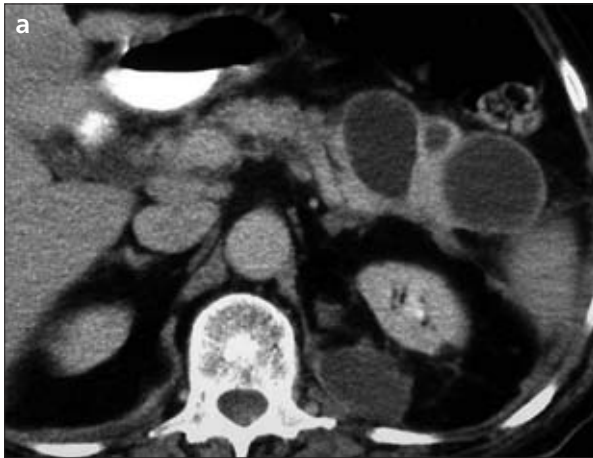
a–c. CT images showing multiple cystic, rim-enhancing pancreatic metastases in a 69-year-old patient with small cell lung carcinoma detected 20 months after initial diagnosis of the primary malignancy.
